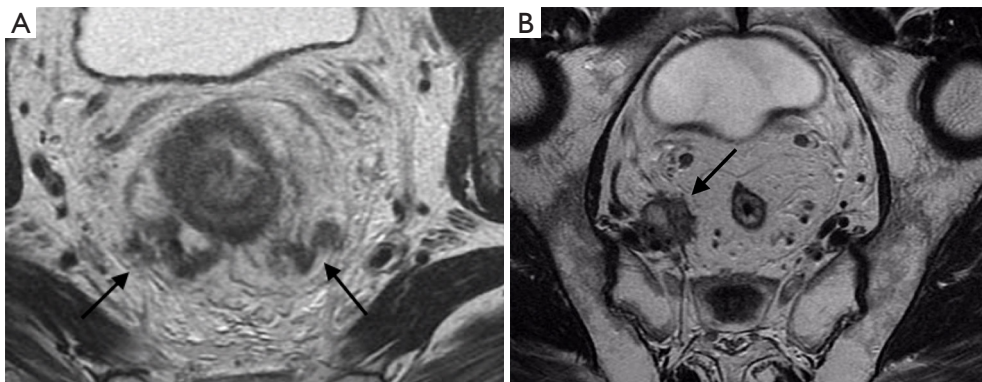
Axial MR images depict positive mrCRM due to (A) EMVI and (B) tumour deposit extending beyond TME, with encasement of the right internal iliac vessels. Neoadjuvant chemoradiotherapy is warranted.
